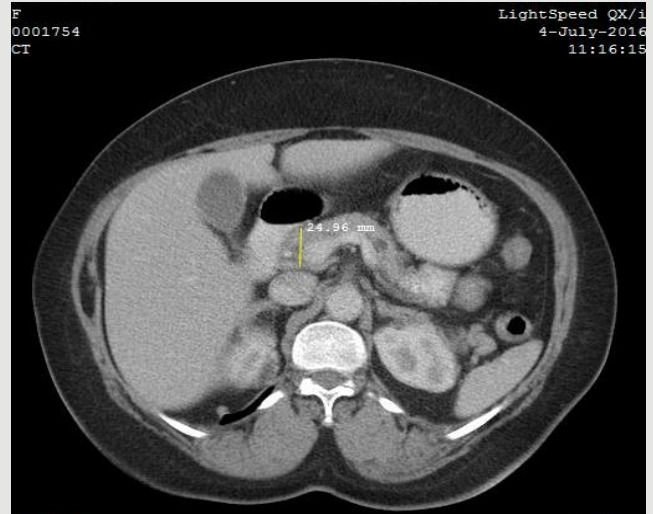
Axial CT Image of the abdomen of an adult female demonstrating the AP measurement of the pancreatic head
